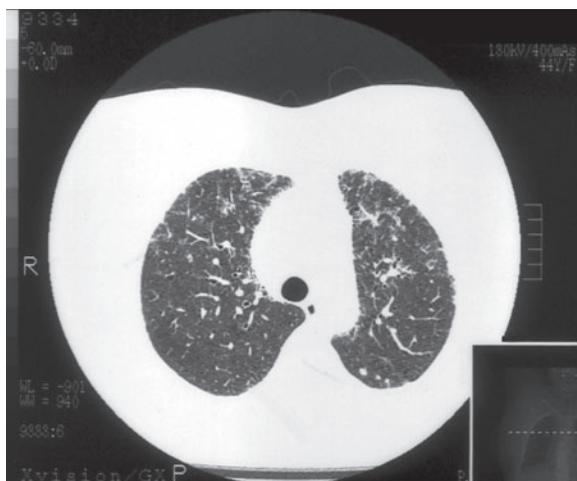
Nodular lesions and subpleural nodules in the upper fields of both lungs in HRCT.
